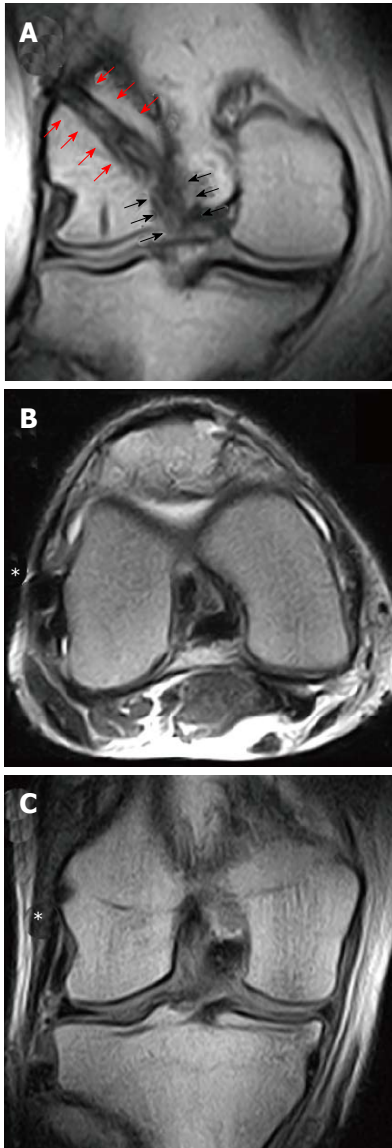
Magnetic resonance imaging evaluation of an anterior cruciate ligament reconstruction with a single-bundle plus lateral extra-articular plasty/augmentation using Gracilis and Semitendinosus Autograft. In the coronal view, it is possible to identify the intra-articular part of the graft (black arrows) that continue proximally above the lateral femoral condyle (red arrows) in the “over-the-top” position (A). The lateral extra-articular plasty (asterisk) could be identified both in axial (B) and coronal view (C) beneath the iliotibial band, extending from the lateral femoral condyle to Gerdy’s tubercle.
